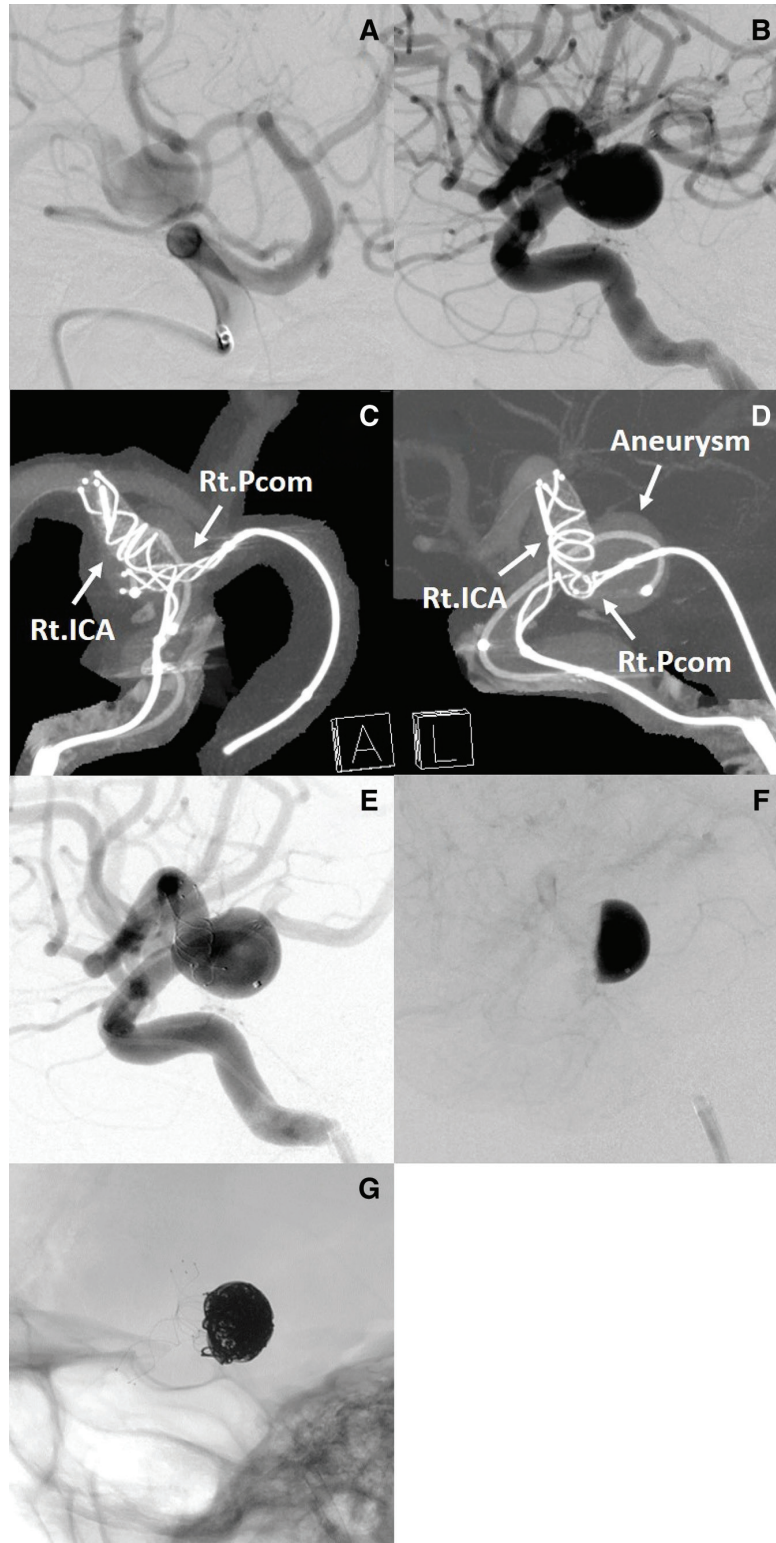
(A) Working angle to guide a microcatheter from the posterior circulation to the posterior communicating artery and internal carotid artery in a retrograde fashion. (B) Working angle for stent placement and coil embolization. T-configuration stenting was confirmed by cone-beam CT (C and D), and both stents were fully deployed. (E and F) Right internal carotid angiography after stent deployment showed the eclipse sign. (G) The coil mass did not reach the orifice of the Pcom artery.
